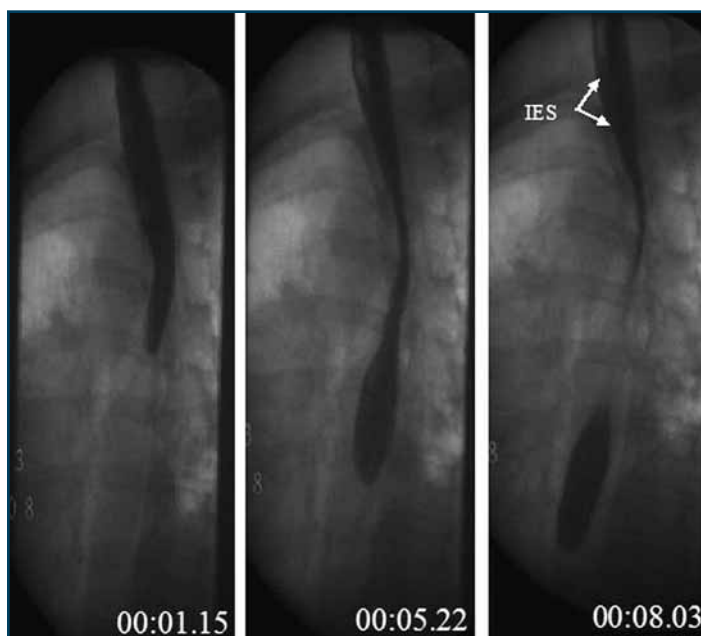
Intraesophageal stasis (IES) observed radiographically following a single swallow of 10mL Varibar semisolid barium by a posttreatment female breast cancer patient.
